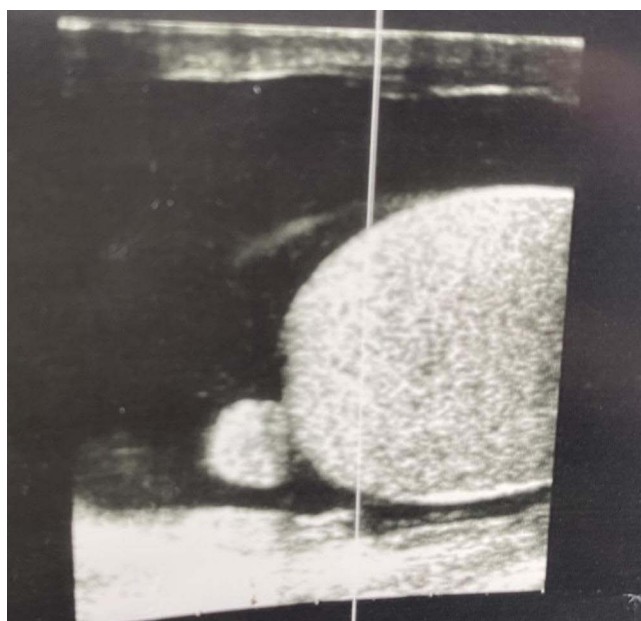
Grayscale scrotal ultrasonography of the right hemiscrotum demonstrating a markedly enlarged testis largely replaced by a well-circumscribed, heterogeneous solid intratesticular mass.
